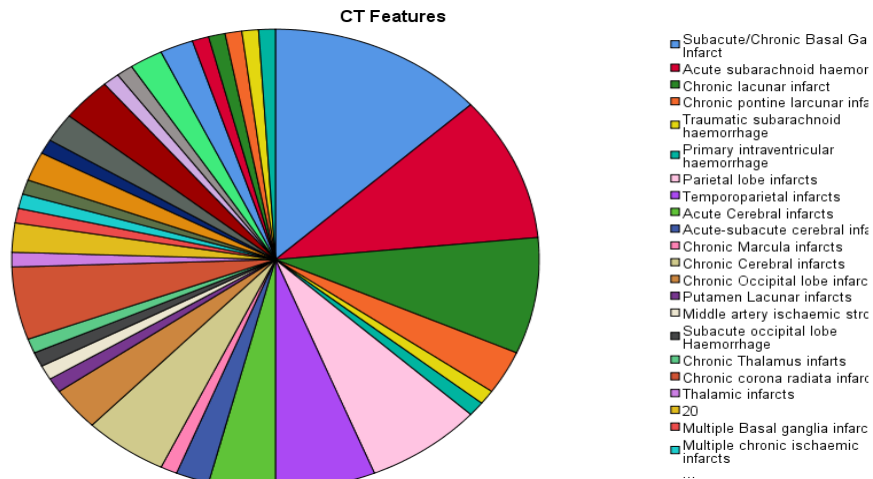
CT features in participants CT diagnostic results.
